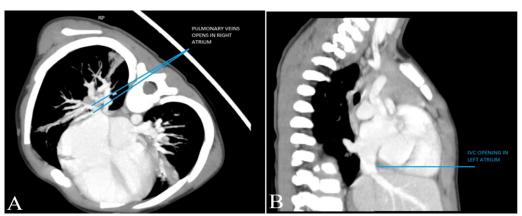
CT scan. A transverse section of CT scan showing right pulmonary veins opening into RA. B Sagittal section of CT scan showing IVC draining into LA.
